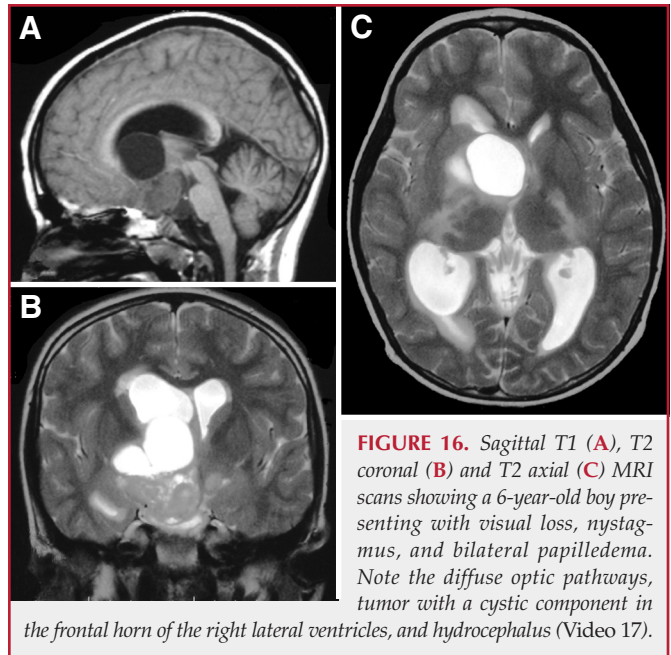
Sagittal T1 (A), T2 coronal (B) and T2 axial (C) MRI scans showing a 6-year-old boy presenting with visual loss, nystagmus, and bilateral papilledema. Note the diffuse optic pathways, tumor with a cystic component in the frontal horn of the right lateral ventricles, and hydrocephalus (Video 17).
